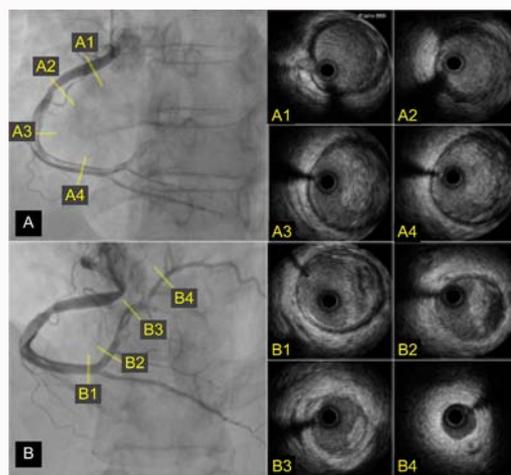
Intravascular ultrasound images from two angles (a, b). (a1) An incipient plaque. (a2) A concentric plaque-causing moderate luminal stenosis. (a3, a4, b1, b2) A subacute-appearing thrombus with a layered light to dark-gray appearance with white patches and less clear delineations. Moderate-to-severe signal attenuation may also be observed, probably due to the deviation or absorption of ultrasound waves by the subacute thrombus. (b3) An acute thrombus (asterisk) with a bright appearance, clear outline, and no signal attenuation. (b4) Discrete intimal thickening.
